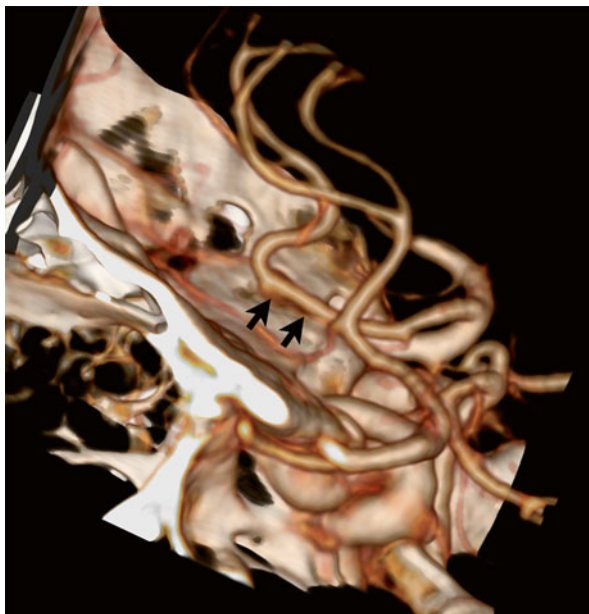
A 32 y/o female presented with a subarachnoid hemorrhage, based on a posterior communicating aneurysm. A persistent median artery as coincidental finding is shown at VR CTA (*arrows*)
